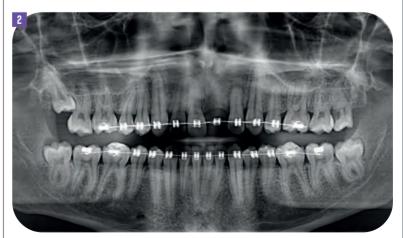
Radiograph taken during orthodontic treatment
